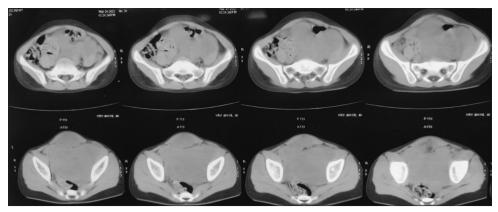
Computed tomography abdomen and pelvis retroperitoneal multiloculated cystic mass, extending from left common iliac region to pelvic region.
